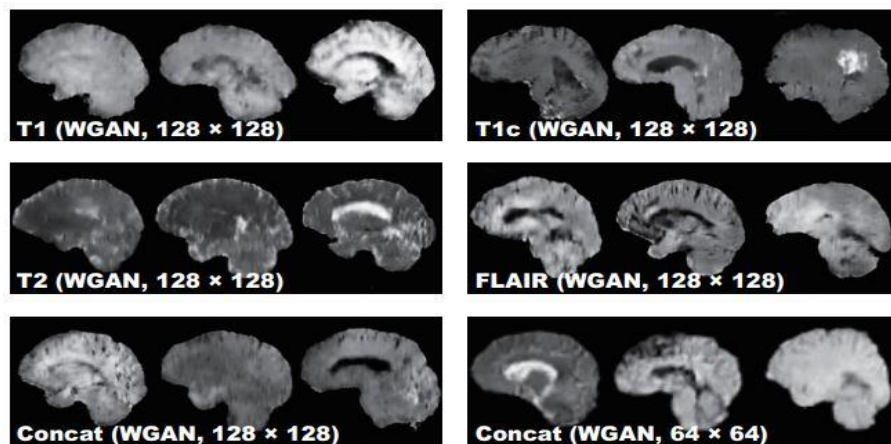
Synthetic MR images based on WGAN.
